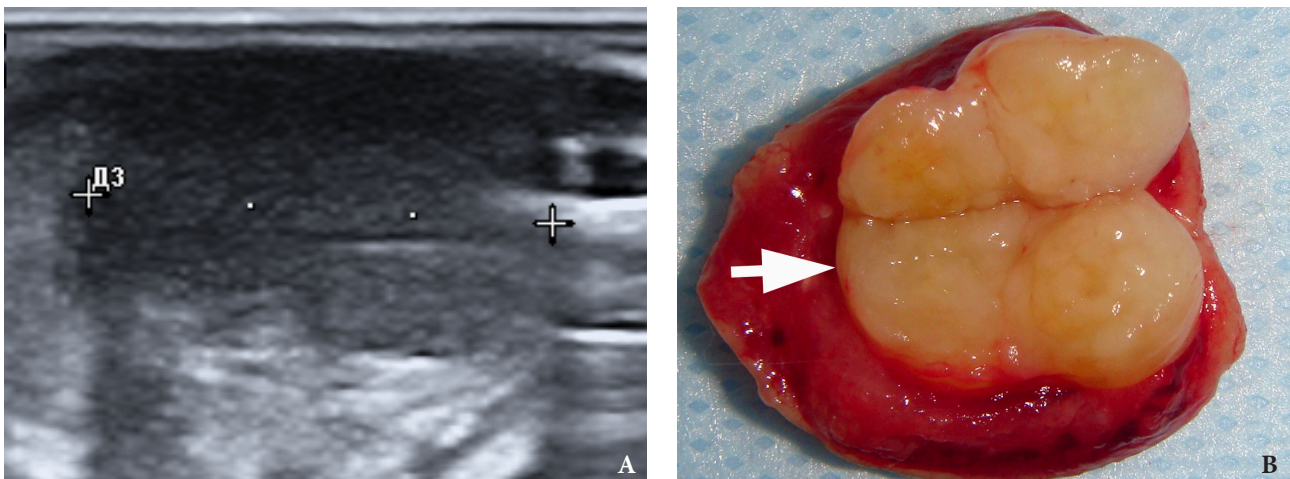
Comparison of the tumor's appearance on gray scale sonogram (A, schwannoma is a heterogeneously hypoechoic mass between '+' calipers) and macroscopically (B, *arrow* labels schwannoma).
